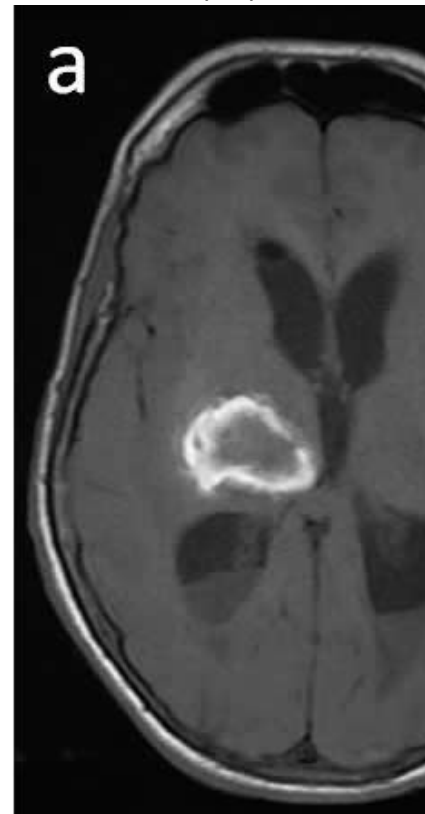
MRI axial cut of a right capsular and thalamic hematoma in the early subacute phase (D3-D7). On T1W1 -the hematoma appears as a central isointensity with a hyperintense rim (a). On T2W1, the hematoma appears hypointense (b).
